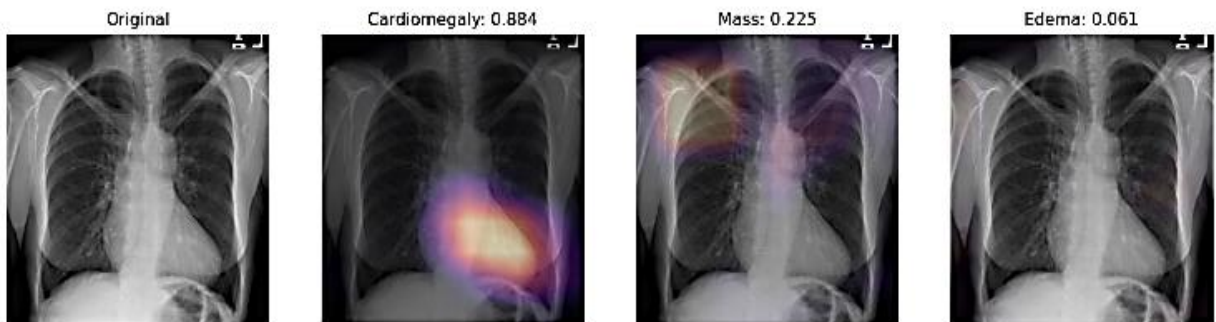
Visual explanation of disease classification results on a chest X-ray Images
